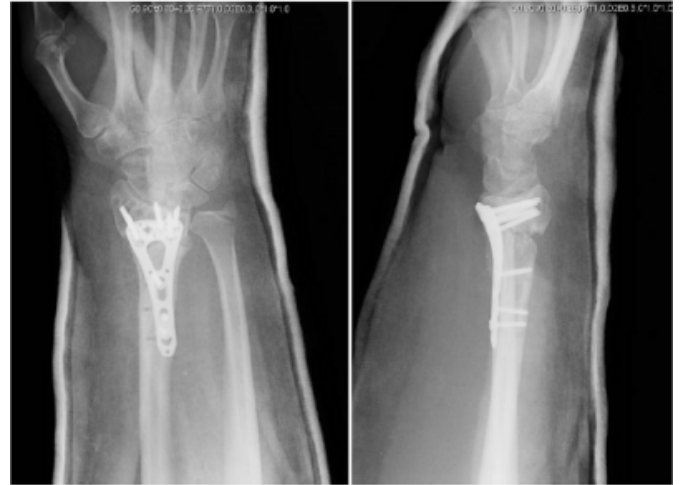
radiographs of the right wrist following initial fixation with a volar locking plate
